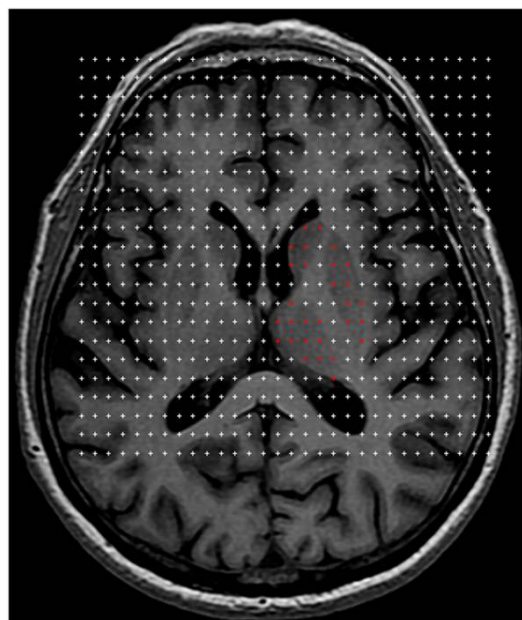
An axial MRI with a point-counting grid superimposed on it for the volume estimation of subcortical structures. Red points hitting the ROI sectioned surface area were counted for each section
